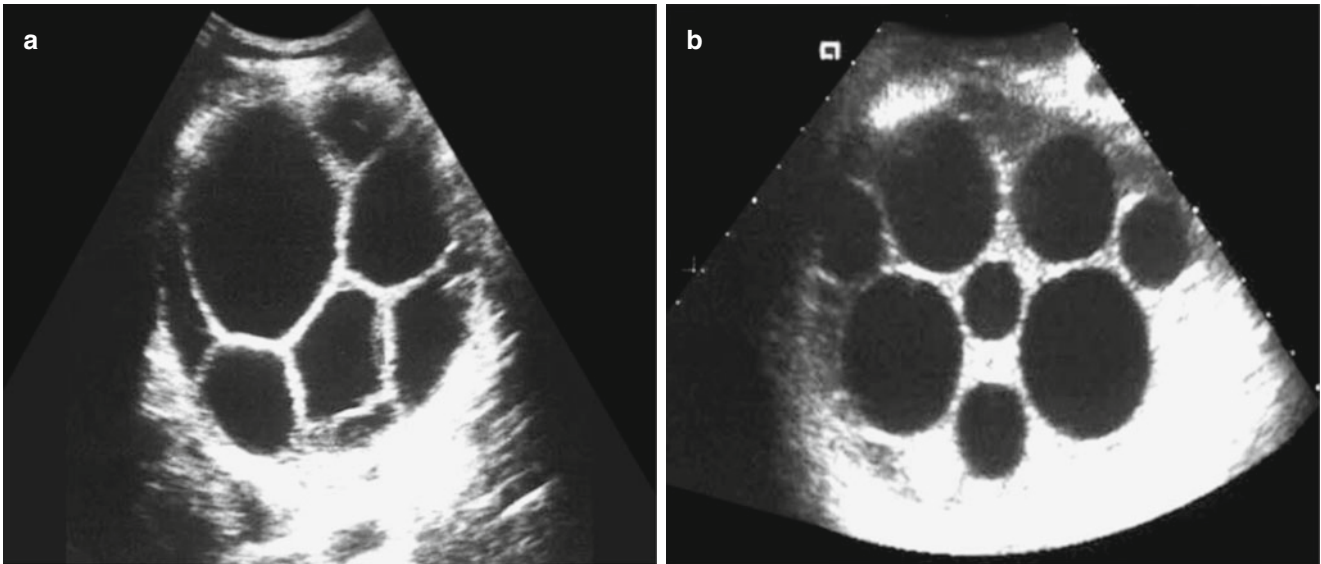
Hepatic cystic hydatidosis (daughter cyst type). (a, b) Ultrasound demonstrates dark areas of small sphere-shaped daughter cysts with different sizes in the mother cyst, with their echo being lower than that of the mother cyst fluid
